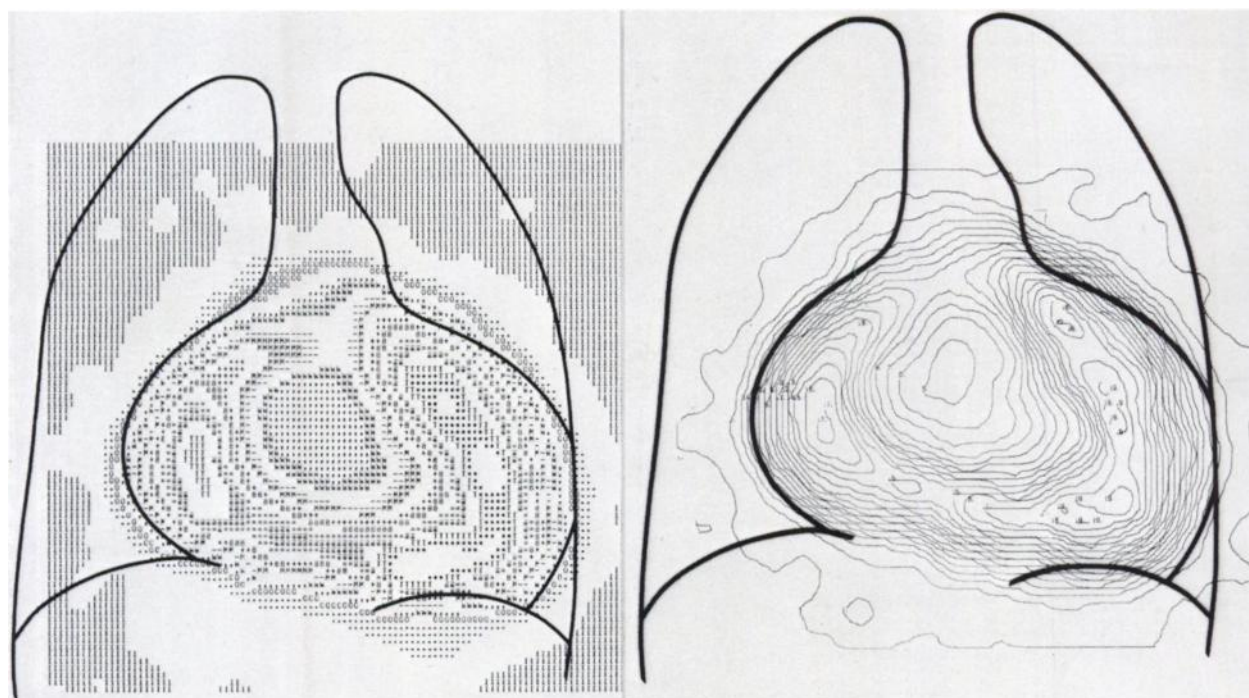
Computer-processed plots of scintigraphic data shown in Figure 1. Left is digitized plot typed by high-speed printer. Right is isointensity contour plot drawn by x-y plotter, depicting 20 levels of activity.
